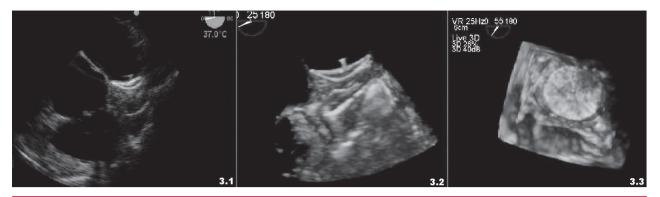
2D (left) and 3D (center and right) echocardiographic images at 3 months, showing a properly implanted device in the LAA with complete exclusion.
